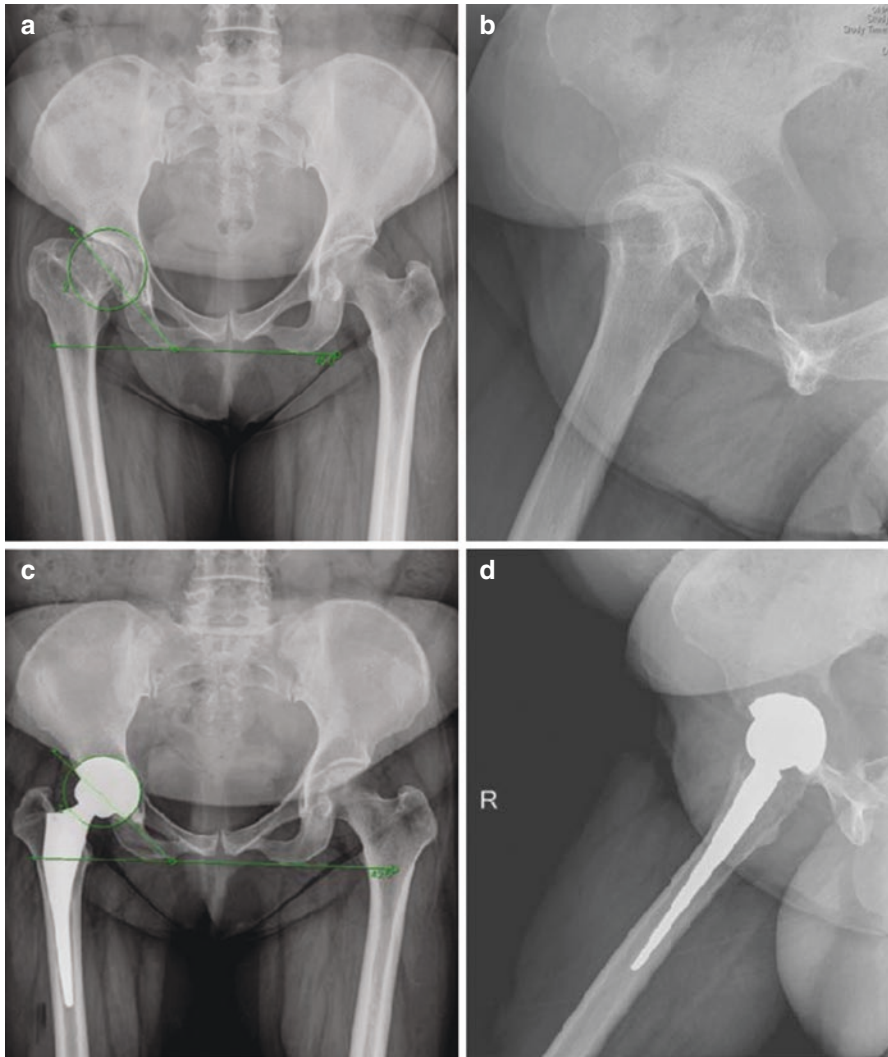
A 48-year-old woman with severe arthritis of the right hip secondary to DDH or Perthes disease. Radiograph showed a severe dysplastic acetabulum (Paprosky type IIA). Plan of cup placement is to achieve medialization as possible (a and b). Radiographs performed 10 months postoperatively showed good cup medialization and well osteointegration of the cup porous surface (c and d) (these pictures were agreed by the patient for publication)
